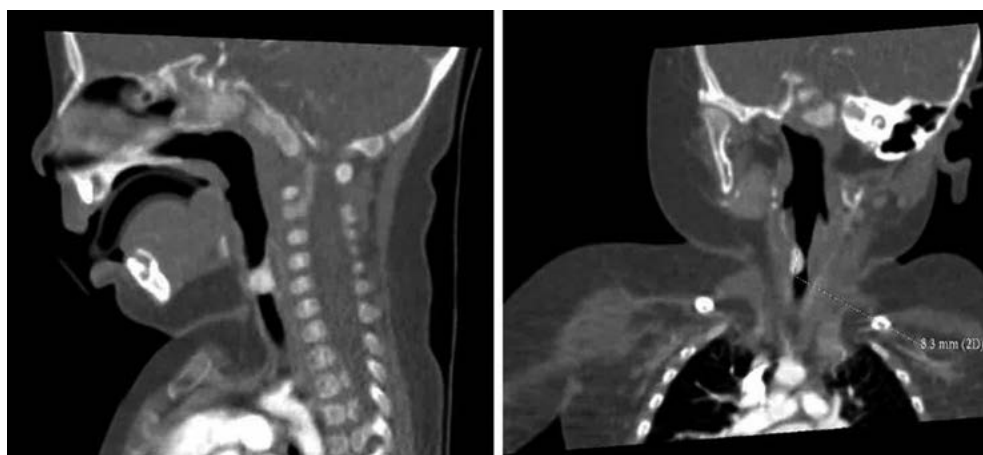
Computerized tomography scan of the neck. The CT scan of the neck reveals a focal mass measuring 8.3 mm, enhancing homogeneously after intravenous contrast administration. The lesion is located in the left subglottic region and is associated with significant secondary laryngeal obstruction.
